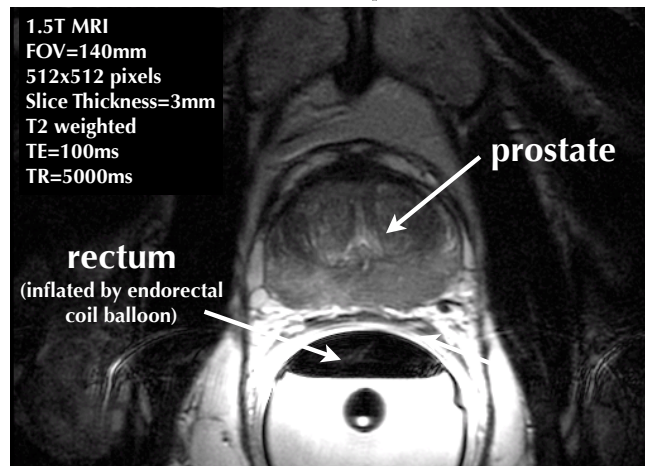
Soft tissue contrast comparison between CT and endorectal coil MRI
